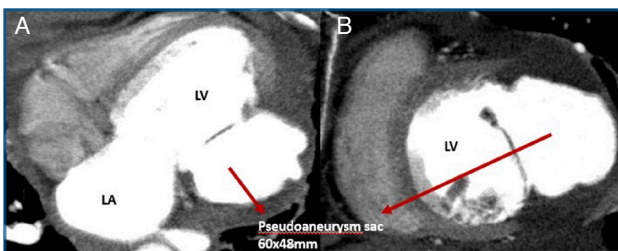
(A, B) Cardiac computed tomography angiographic image of the 60 × 48 mm pseudoaneurysm sac.
